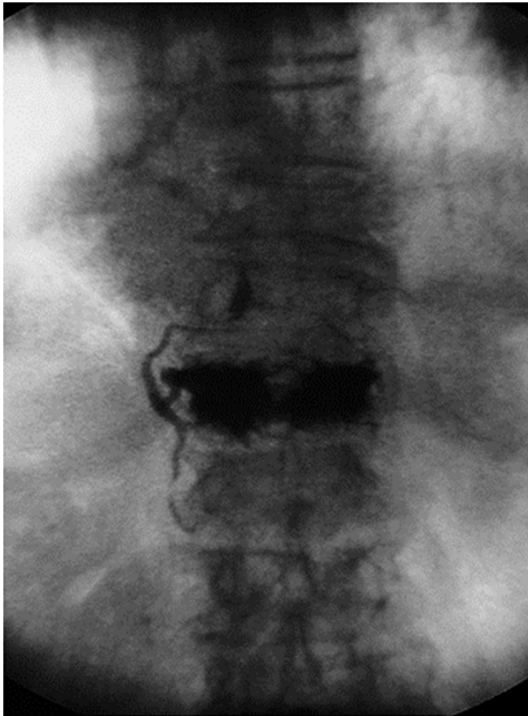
X-ray imaging of bone cement leakage of a 64 years old female OVCFs patient who had taken PKP treatment at T12. Bone cement leakage along the paravertebral vein was found during the operation. Because the patient did not feel any discomfort, no special treatment was taken.
